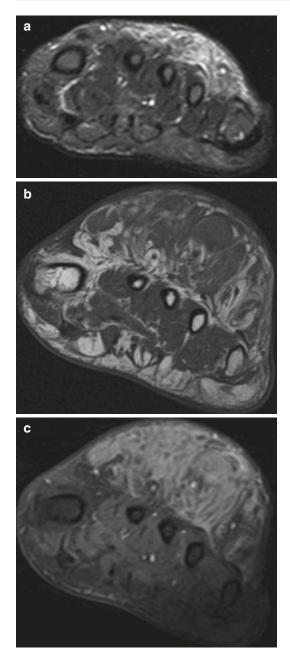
49-year-old female with PHAT in the foot. (a) Axial proton density–weighted MR-image with fat saturation. (b) Short axis T1-weighted MR-image. (c) Short axis T1-weighted post-contrast image with fat saturation. Proton density–weighted images (a) with fat saturation shows ill-defined hyperintense signal in the subcutaneous tissues at the dorsum of the forefoot over the metatarsal shafts. Short axis T1-weighted image (b) from subsequent MRI 3 years later demonstrates significant interval growth of the ill-defined soft tissue mass. Short axis post-contrast image (c) demonstrates diffuse enhancement within the mass on the later exam. Note interspersed fat signal throughout the lesion and ill-defined margins
